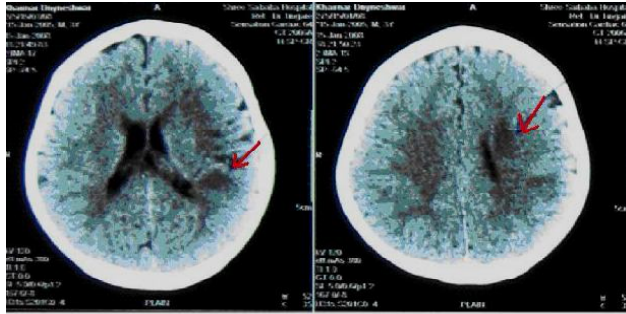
Showing CT scan of brain
